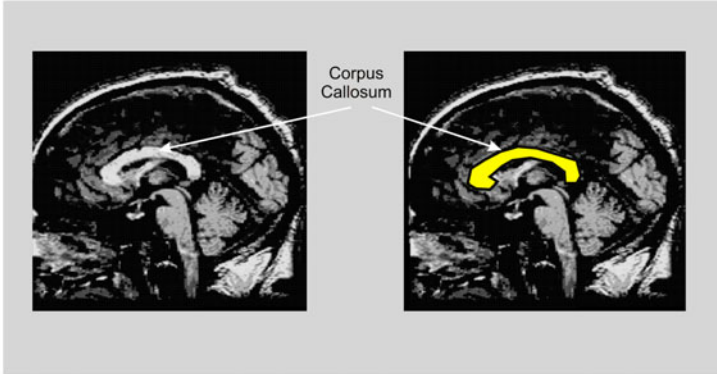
Midsagittal MRI brain scan slice showing the corpus callosum (highlighted in the right-hand image)
